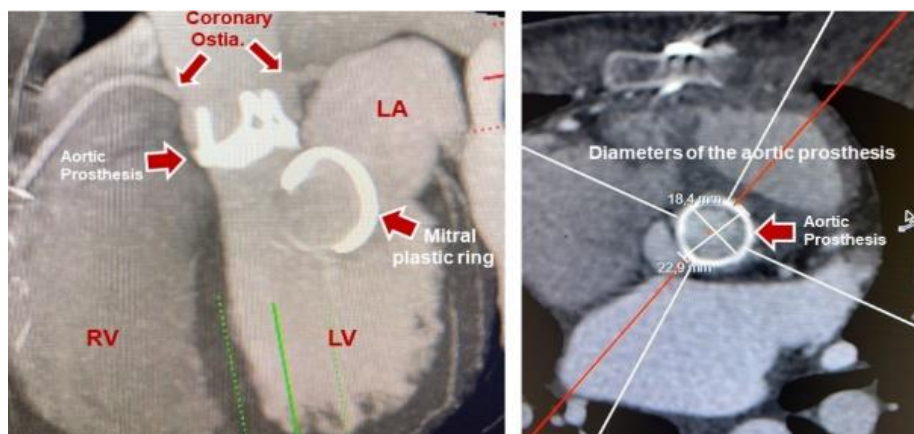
Computed Tomography Angiographic images show the aortic route, aortic prosthesis, coronary Ostia position, and mitral annuloplasty. (September 22, 2022)
